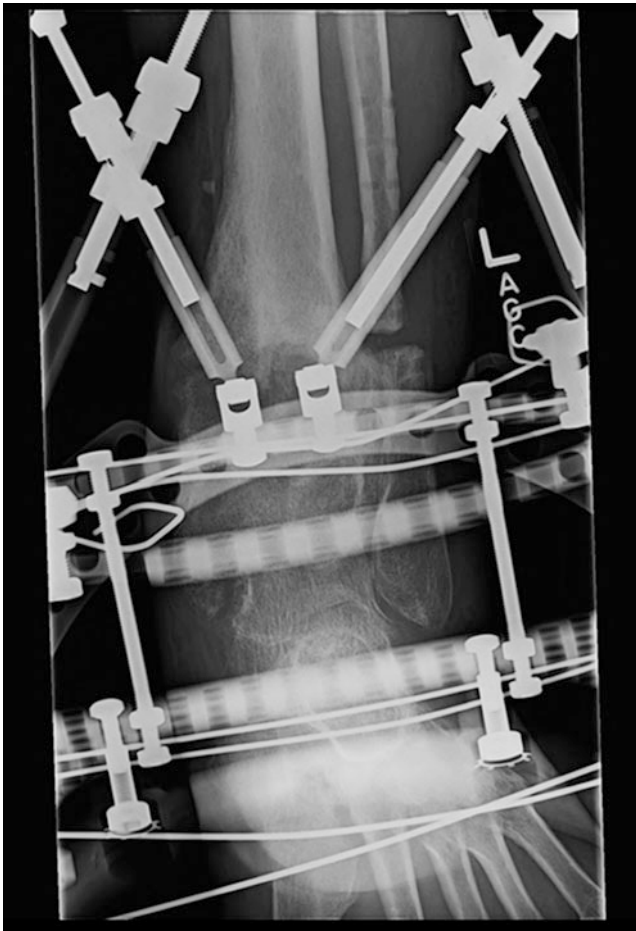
Radiograph after 10 weeks of gradual correction. The fibular osteotomy space is minimal
